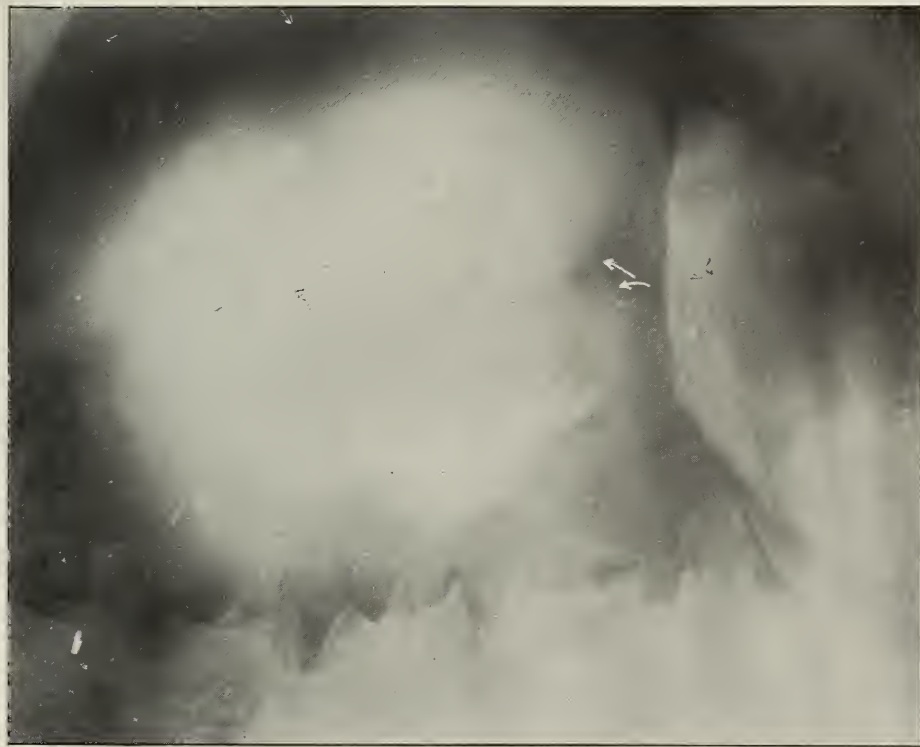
X-ray No. 9139. Region: left lumbar. The presence of large tumor indicated a shadow plate of the renal pelvis to differentiate the tumor mass from kidney. Note shadow of tumor overlapping outer portion of kidney. Renal pelvis normal. At operation tumor proved to be spleen.
